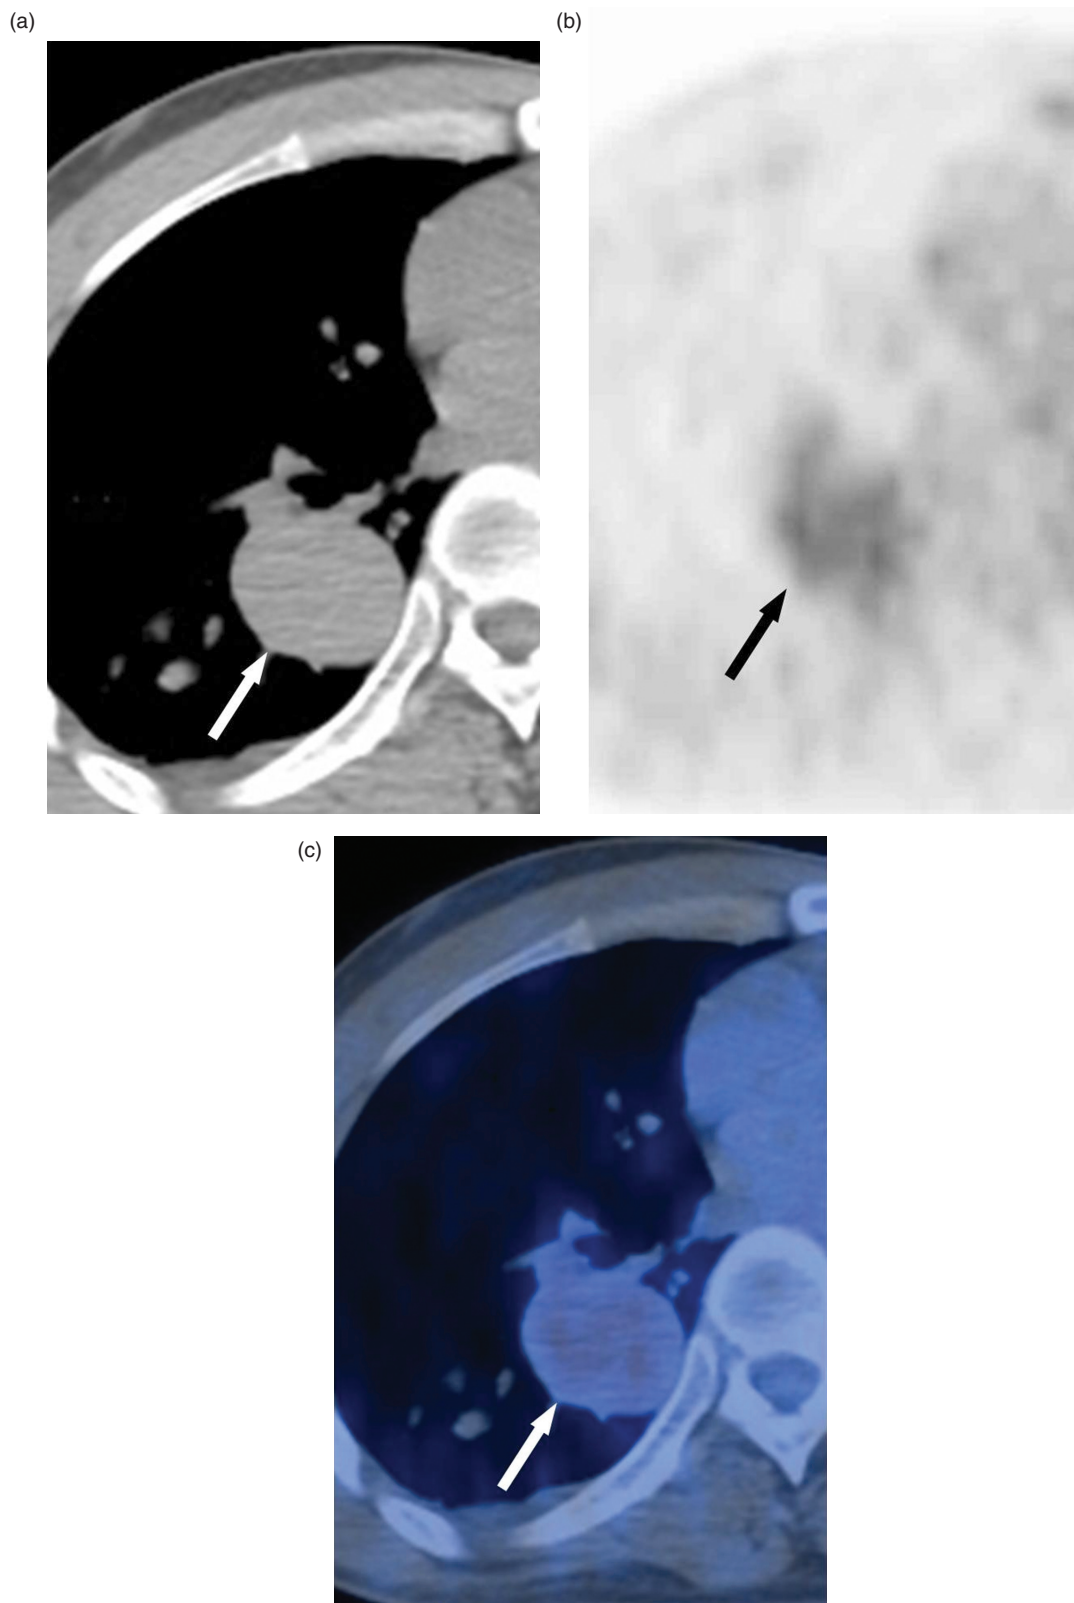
A 56-year-old man with typical carcinoid (T2N0M0, IB). (a) Transverse unenhanced CT scan (5-mm section thickness, 40 mAs) obtained at the level of the right inferior pulmonary vein shows a 42-mm-sized mass (arrow) in the right lower lobe. (b),(c) FDG PET (b) and integrated PET/CT (c) scans show little FDG uptake (arrow) within the tumor (SUV_{max} , 3.4).
